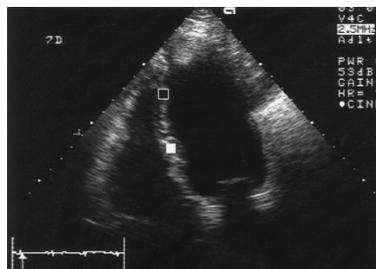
shows the acquired data for the apical 4-chamber view of the transthoracic Echocardiogram sample in use from usual and infarcted myocardium represented as white (normal) and black (infarcted) squares.
